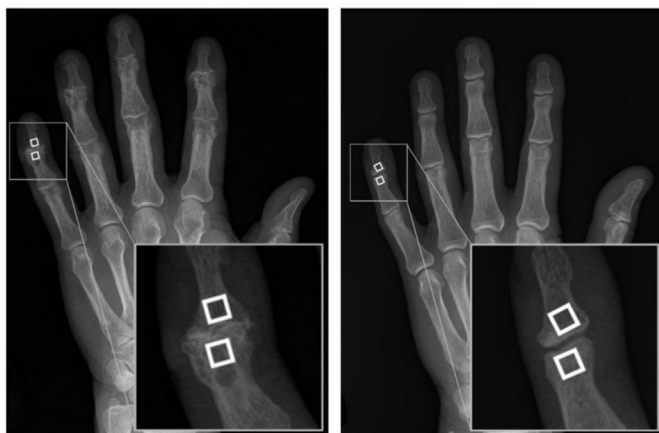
X-rays of hands (left) with and (right) without radiographic OA in the DIP5 joint. White squares are bone texture regions selected.
